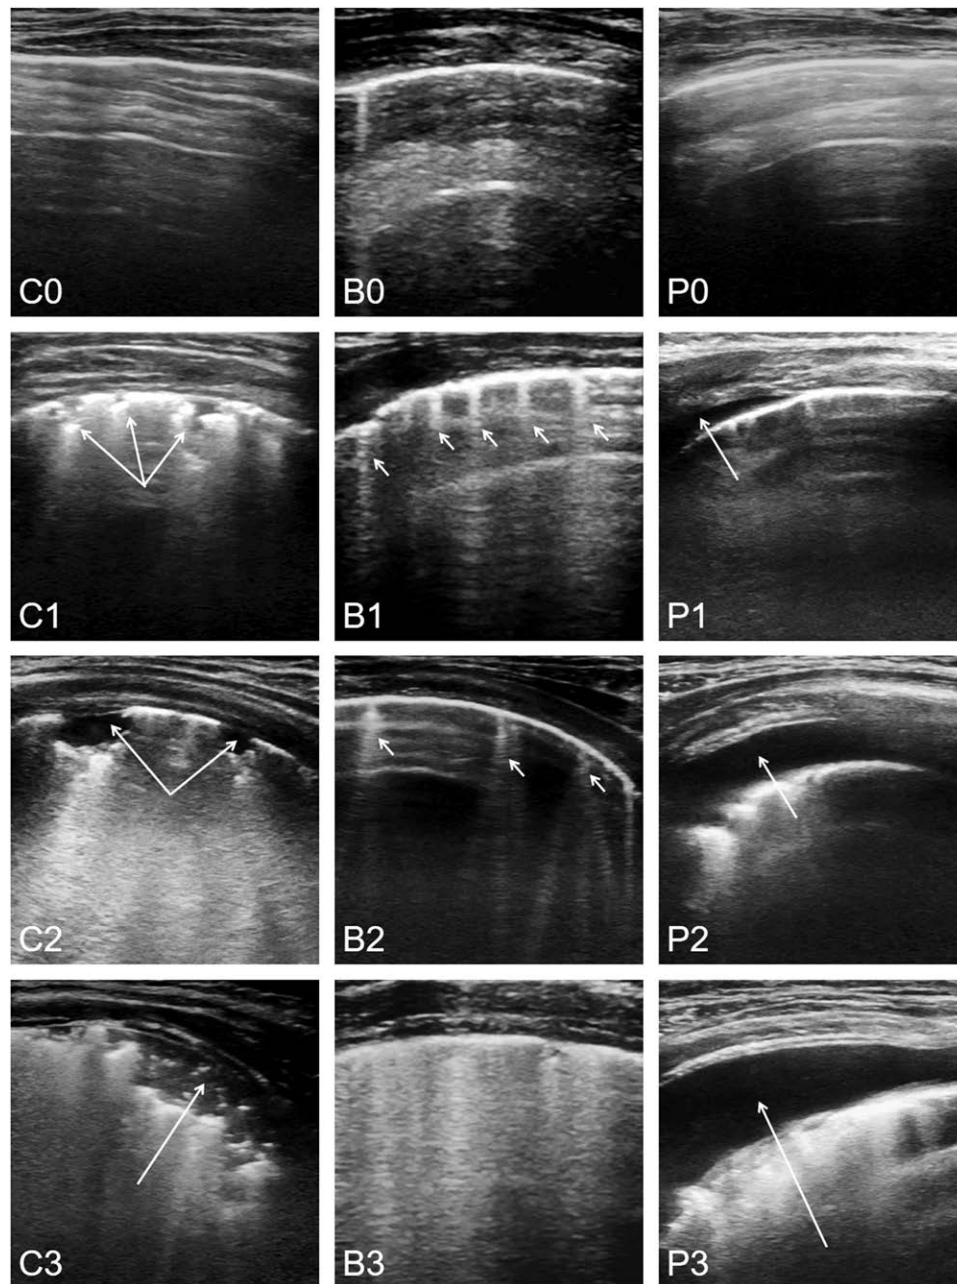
Lung ultrasound findings of consolidations, B-lines, and pleural effusion. The degree of consolidations was divided into four grades: C0, no consolidation; C1, minimal juxtapleural consolidations; C2, small-sized consolidations; and C3, large-sized consolidations. The degree of B-lines was divided into four grades: B0, fewer than three isolated B-lines; B1, multiple well-defined B-lines; B2, multiple coalescent B-lines; and B3, white lung. The degree of pleural effusion was divided into four grades: P0, no pleural effusion; P1, minimal pleural effusion; P2, small amount of pleural effusion; and P3, moderate amount of pleural effusion. Each *arrow* indicates pathologic findings in each figure.
